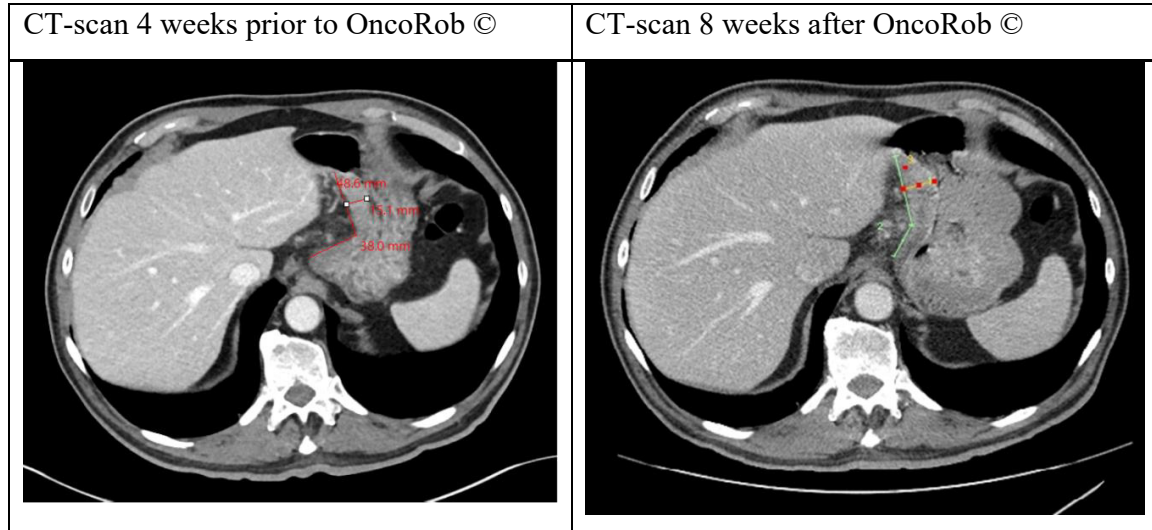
Gastric Cancer Patient’s CT Scan Results Pre and Post OncoRob © Treatment
